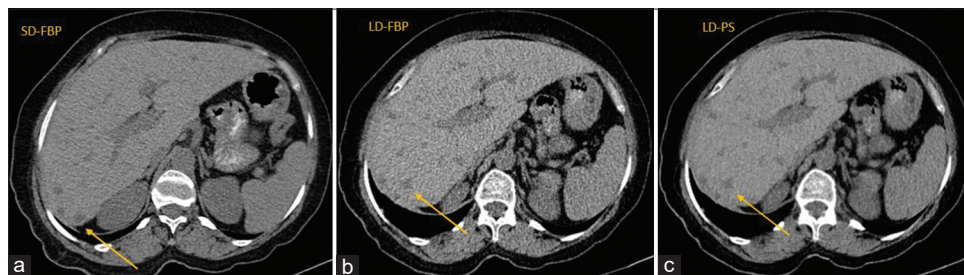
Computed tomography (CT)-guided biopsy procedure performed on scanner A, planning phase scan (a) at standard dose with 260 mA and 110 kV and targeting phase at 50% dose reduction, i.e. 130 mA and 120 kV and low-dose images were reconstructed by filtered back projection (b), and PixelShine (PS) reconstruction (c). PS image shows lower noise (less grainy). Although the image appears smooth, the sub-centimeter-sized liver lesion (arrow) conspicuity is not lost and its margin and shape are maintained. SD: Standard dose, FEP: Filtered back projection, LD: Low dose, PS: PixelShine
